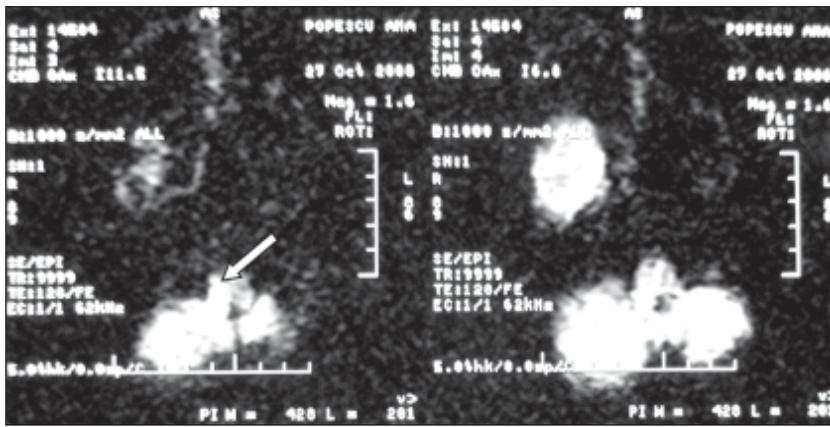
Cerebral MRI – DWI sequence – hyperintense signal in the posterior part of the right medulla and pons
